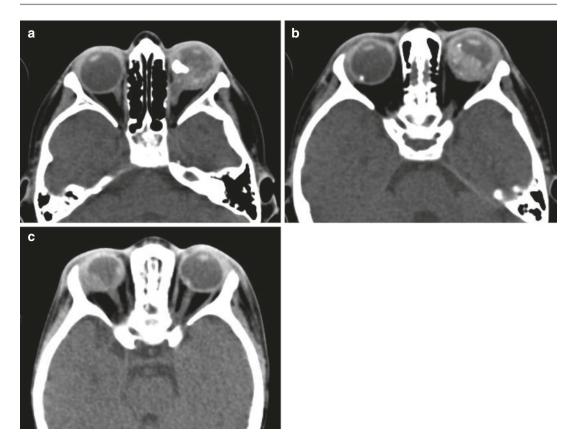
Axial CT scans of the orbit of different patients showing the types of calcification seen in retinoblastoma. (a) Clump like. (b) Multifocal speckled. (c) Single dense
